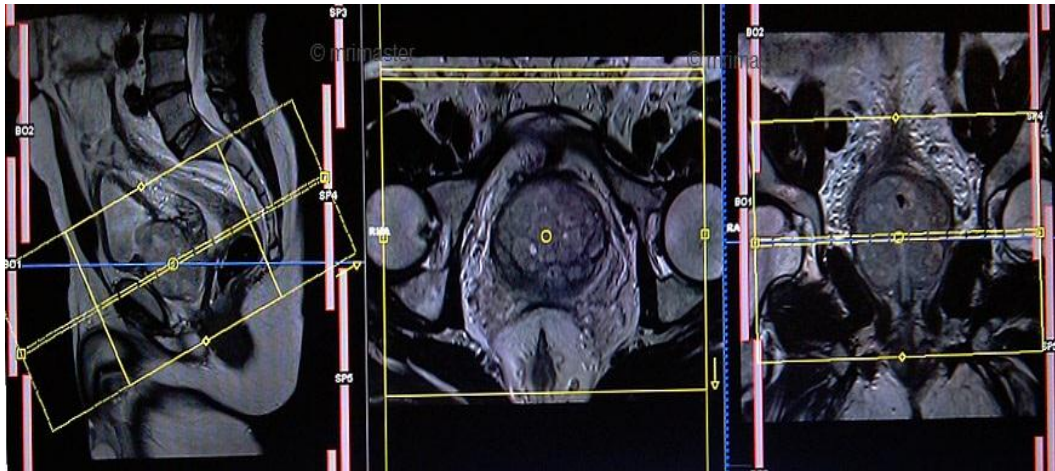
localizer images of prostate MRI examination
